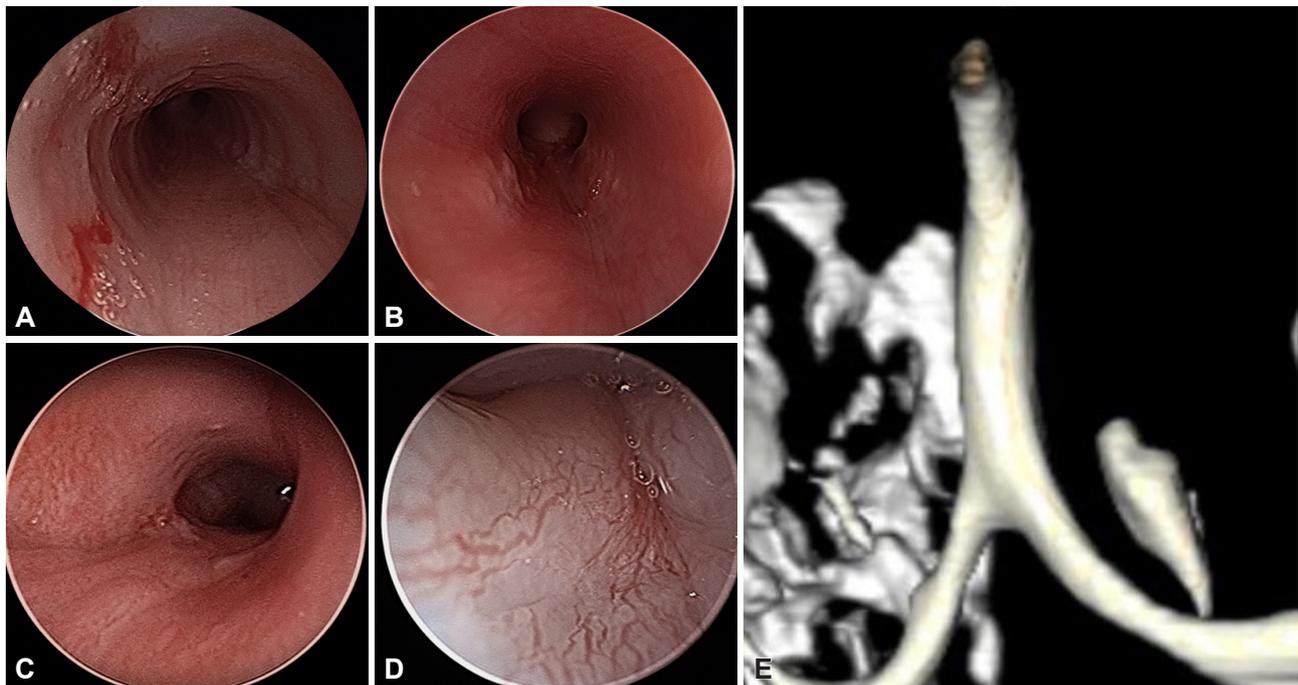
Direct laryngoscopic view and three-dimensional CT reconstructions. A: Normal trachea with separated tracheal rings. B: TCS showing smooth wall without notifiable tracheal rings. C: TCS extending to right sided segmental bronchus. D: Endoscopic view showing choanal narrowing. E: Three-dimensional CT reconstructed image showing absence of C-shaped tracheal rings. TCS, tracheal cartilaginous sleeve.
